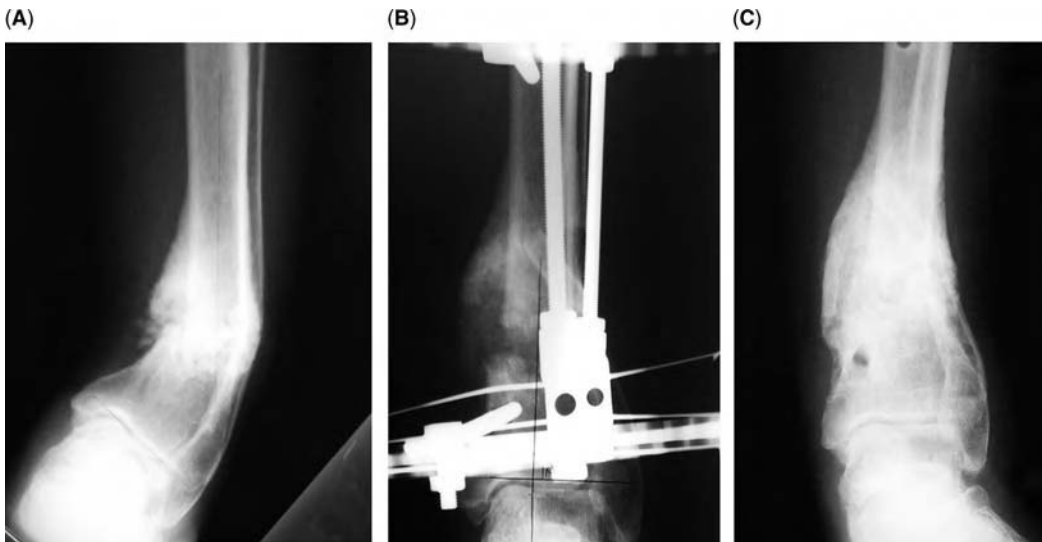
(A) Anteroposterior X-ray showing a stiff nonunion with large varus deformity in a blind diabetic patient. This patient had a lateral ulcer at the apex of the fibula deformity. (B) Four weeks after application of the Ilizarov frame. The nonunion was not exposed and gradual distraction correction was performed. (C) Six months after frame removal showing healed nonunion without deformity.
